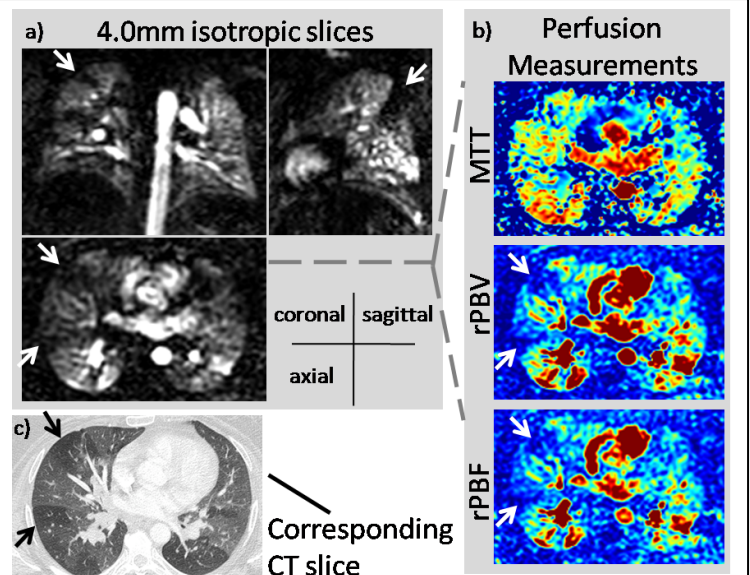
Patient with sarcoidosis (1.5T, 8-channel cardiac coil). a) Representative slices at the peak parenchymal enhancement phase. b) Reduced rPBV and rPBF color coded values are observed (arrows) at the same locations. c) A CT slice of the same patient showing air trapping (arrows). MR Perfusion defects (white arrows) correlate with areas of air trapping seen on CT (black arrows).
